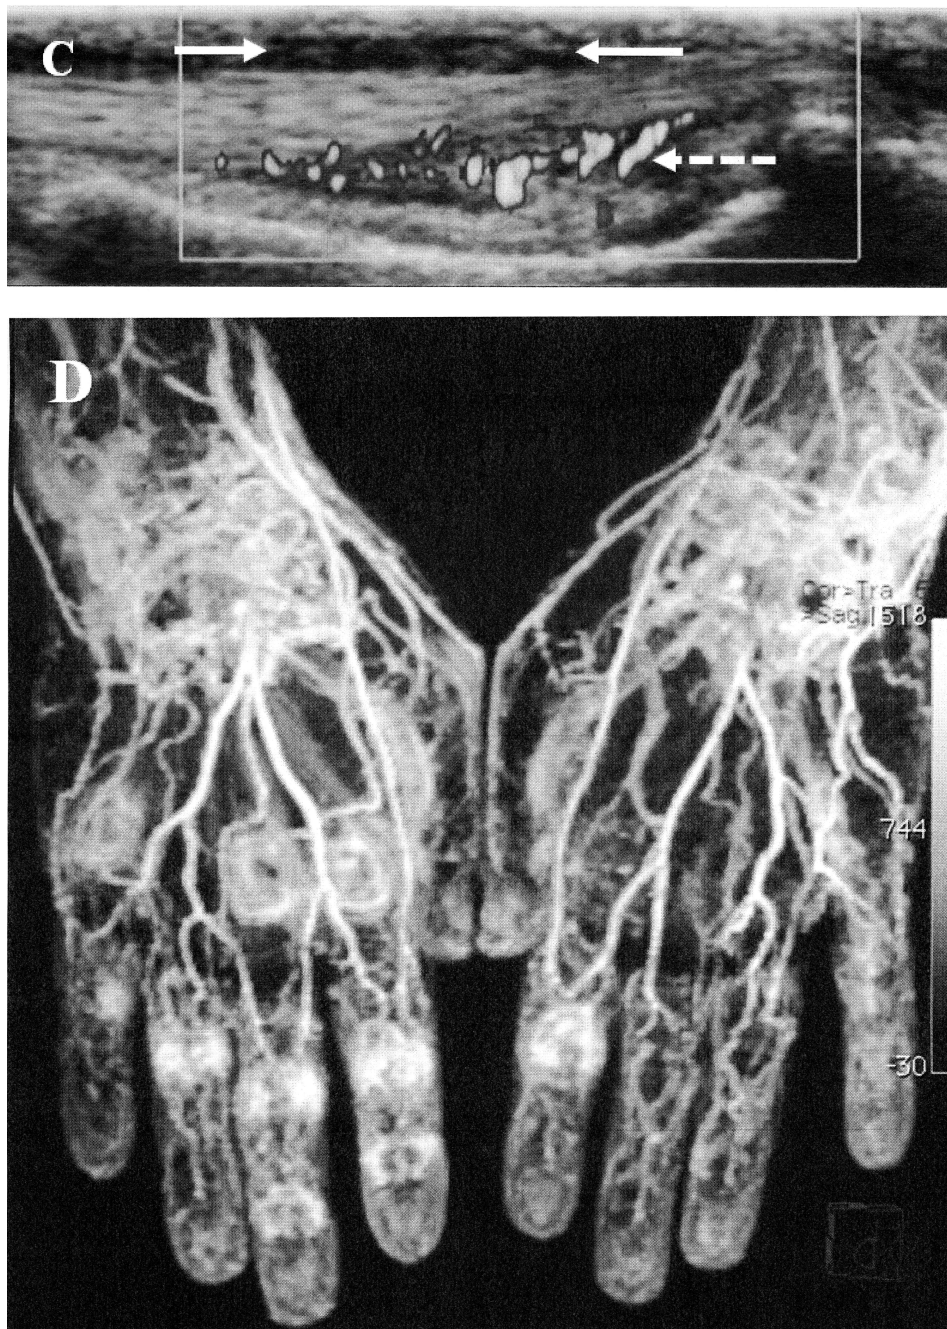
1D. (C) Ultrasound examination of the fifth digit on the left hand demonstrating tenosynovitis (arrows) and active power Doppler signal (dashed arrows). (D) Magnetic resonance maximum intensity projection of a 3-D digitally subtracted dataset of the volumetric interpolated breath-hold examination acquisition after contrast administration. The image demonstrates increased vascularity of synovitis of carpal, metacarpophalangeal, and interphalangeal joints. The tubelike appearance of digit tenosynovitis is also clearly depicted.
